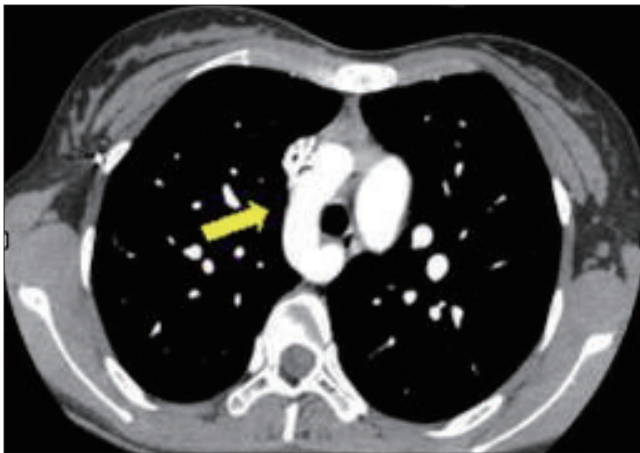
Chest dynamic computed tomography showed right sided aortic arch (arrow).
